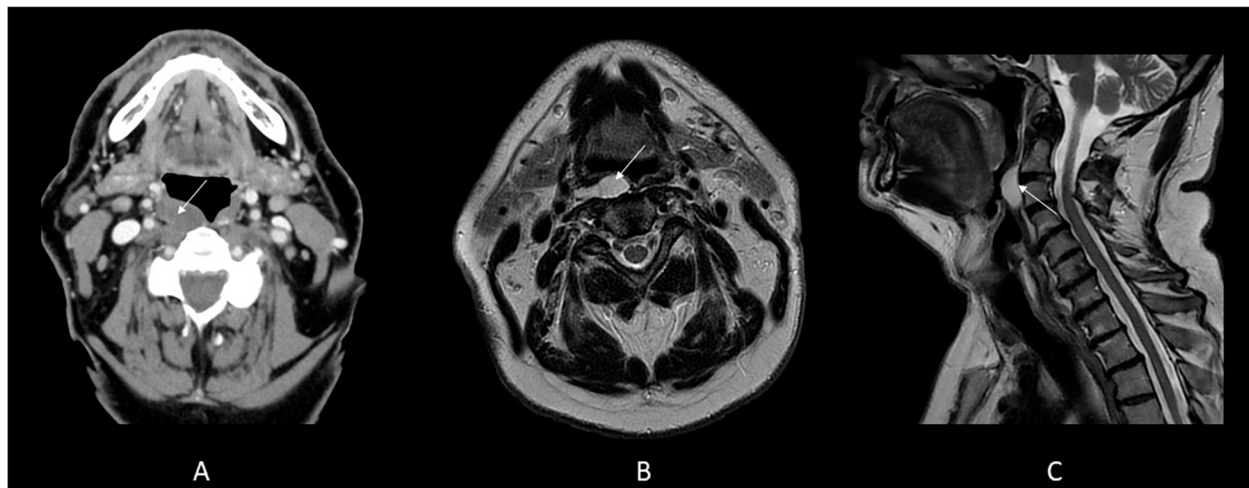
Contrast-enhanced CT scan imaging of the neck: encapsulated mass (white arrow) occupying the retropharyngeal space, expanding on the right side, in close contact with carotid sheath (A). MRI axial and sagittal scans with gadolinium showed a retropharyngeal lesion with uniform high signal intensity in T2-weighted images (B and C). Note that the mass, arising from the retropharyngeal space, causes anterior displacement of the pharyngeal mucosa, leading to the pharyngeal globus sensation. CT, computed tomography. MRI, magnetic resonance imaging
